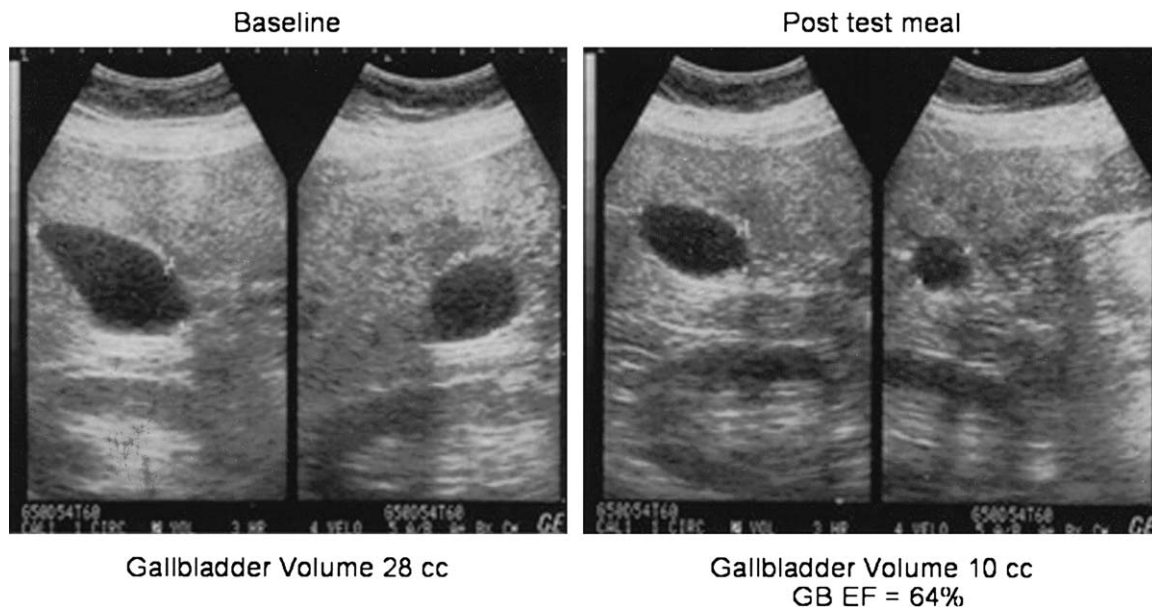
Gallbladder (GB) ultrasounds and ejection fraction (EF).
